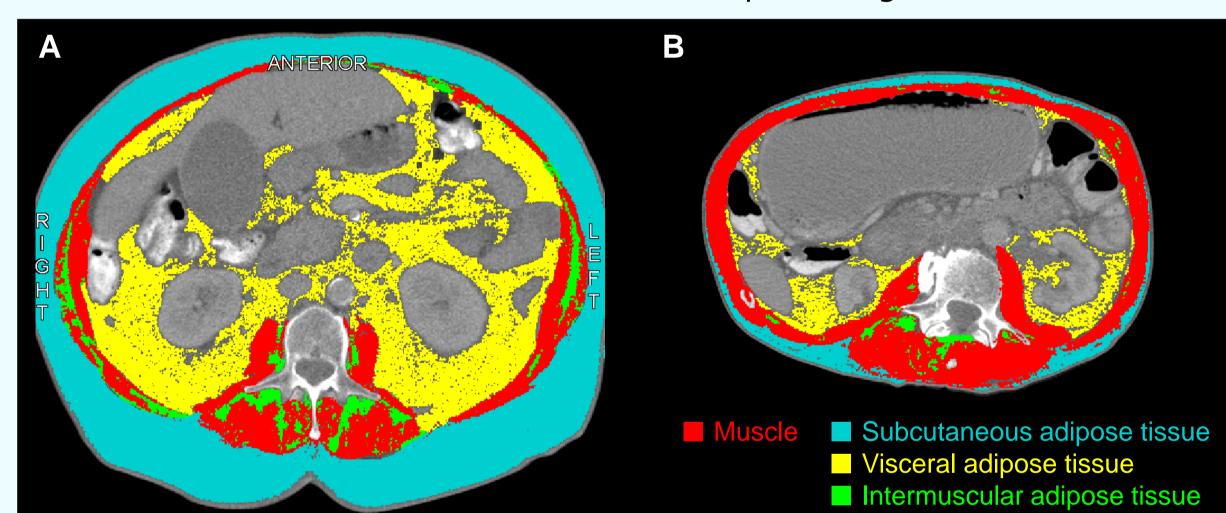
CT analysis at L3 level of an overweight (A) and a lean (B) patient.
